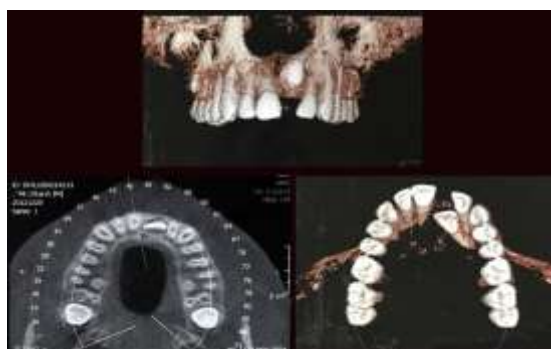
Cone beam computed tomography images of impacted central incisor
